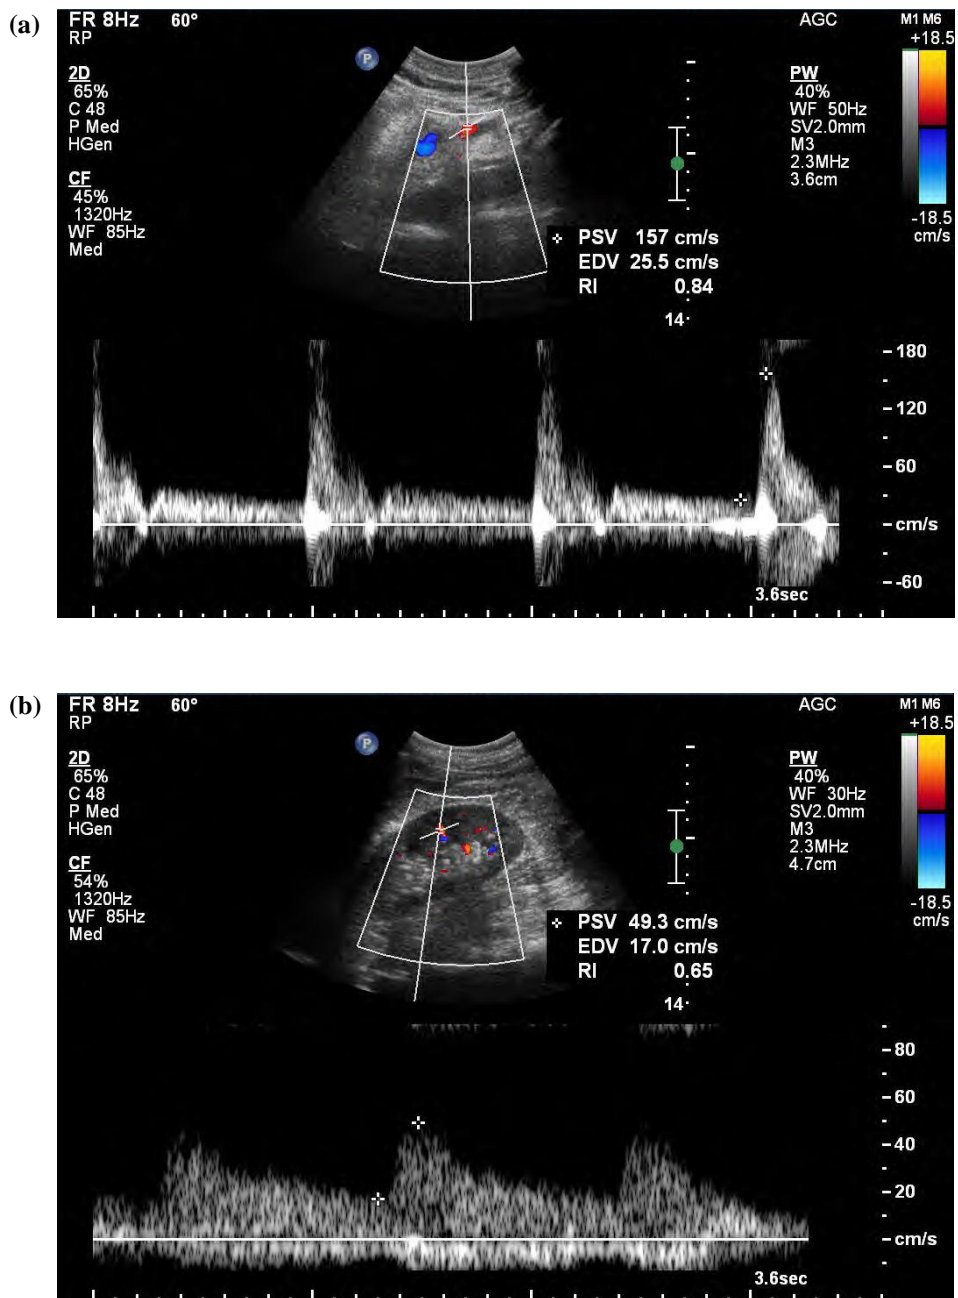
Doppler US image of (a) SMA and (b) intrarenal artery at fasting state in a 44-year-old man who underwent total gastrectomy 49 days ago.
